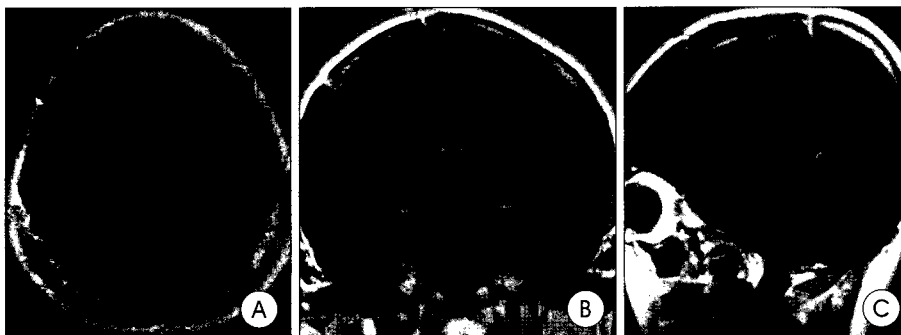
Postoperative enhanced T1 axial (A), coronal (B), sagittal (C) magnetic resonance imaging show no residual mass eight months after operation.
